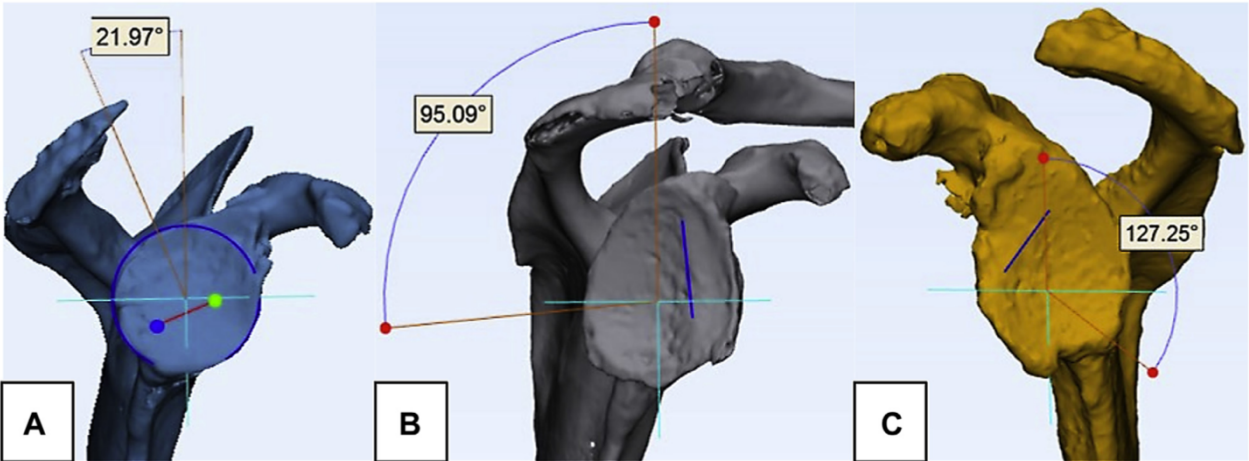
3D CT representation of the erosion orientation in type B2 biconcave glenoids. A, posterior-superior, B, posterior-central, and C, posterior-inferior wear patterns⁹⁶.
